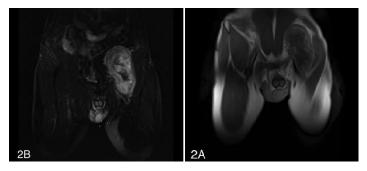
(A) MR imaging showed a heterogeneous hypointense signal on T1 sequence with losing fat plane in the left iliopsoas muscle. (B) High intensity and heterogeneous signal in T2 sequence with fat saturation after administered gadolinium heterogeneous enhancement
